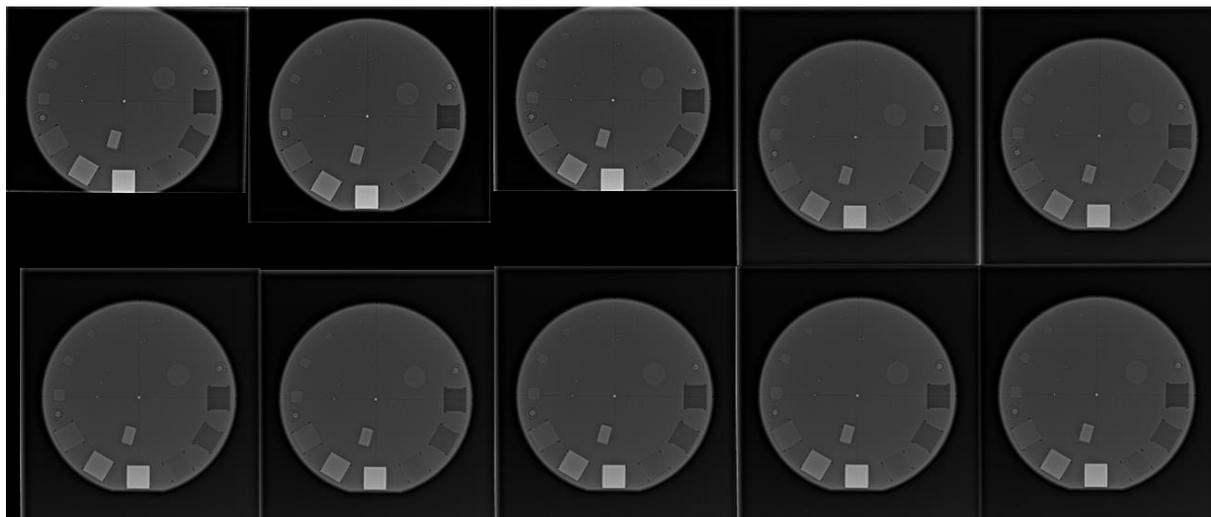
General x-ray reproducibility images.
